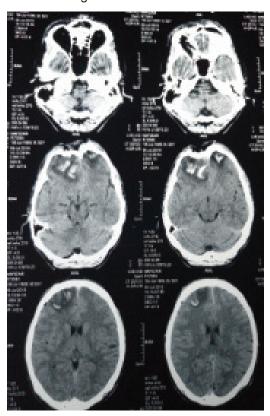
CT scan shows frontal depressed fracture with hemorrhagic contusion.
